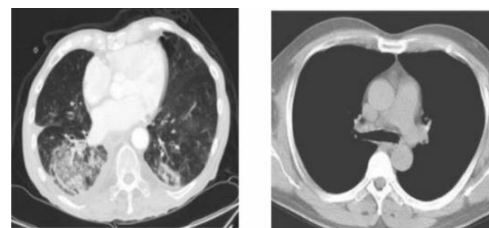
Sample Non-Covid CT Scan Images
